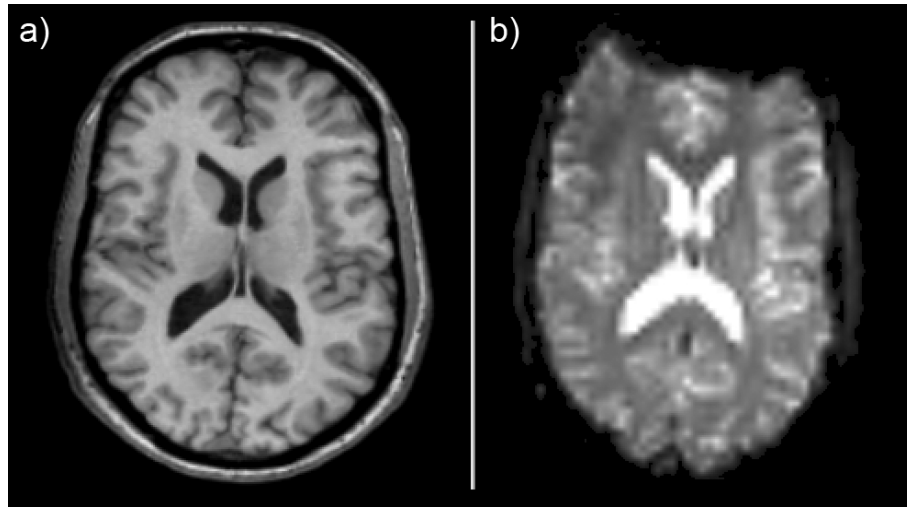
MR images of the same section with different tissue contrasts. a) shows a  $T_1$ -weighted high resolution volume scan and b) a low resolution  $T_2^*$ -weighted image acquired with echo planar imaging (EPI). Depending on the TR chosen, it is possible to highlight different aspects in the image like for example the gray-white matter boundary in a).
